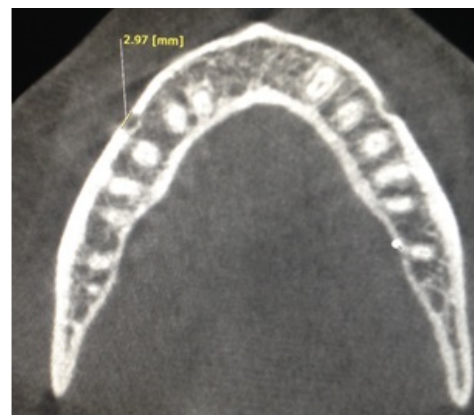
Mesiodistal dimension of the mental foramen (CBCT-axial section)
